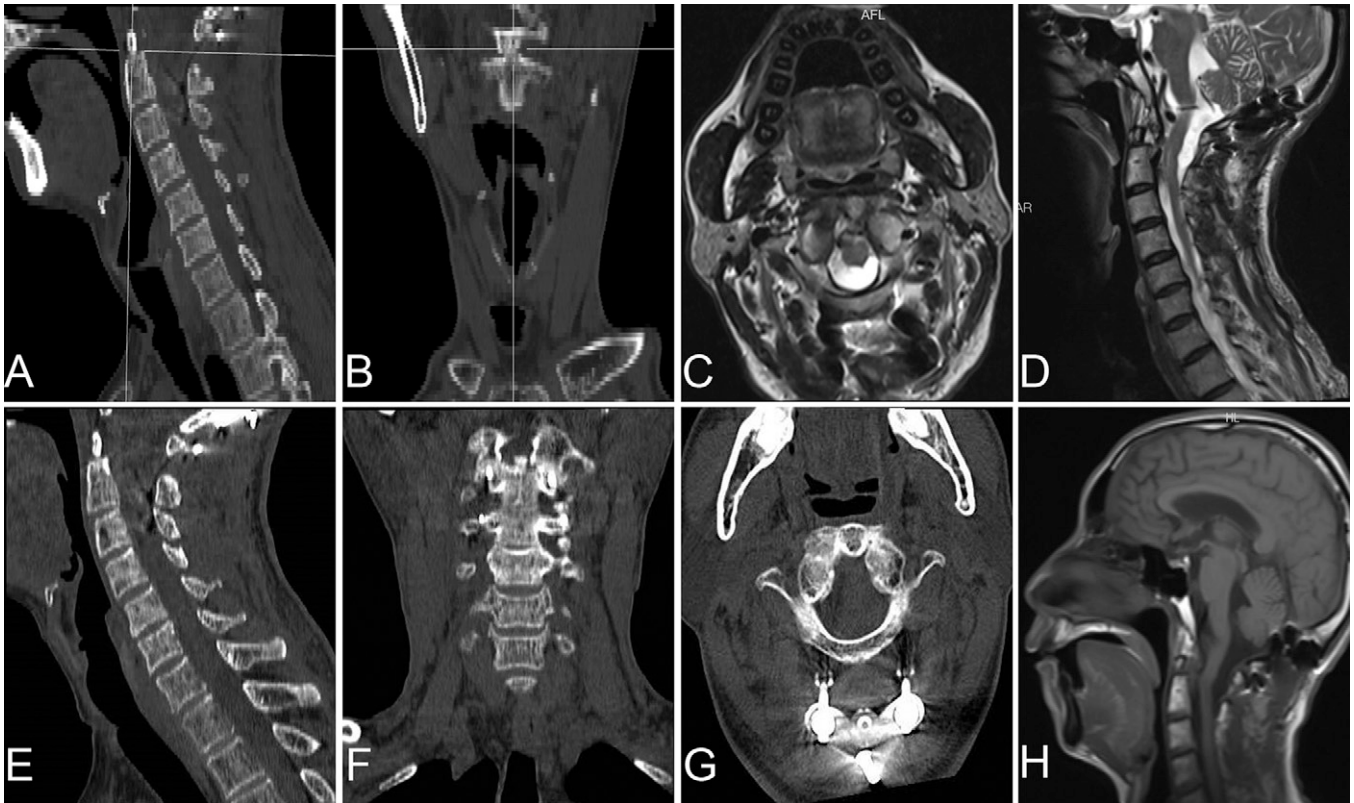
At the 3-month follow-up, CT revealed bony fusion between the lateral joints of C1–2 and between the root of the resected odontoid process and the anterior arch of C1 (A and B). MRI showed an arachnoid cyst lying posterior to the cervical cord at the level of C1–2 (C and D). At the 12-month follow-up, CT showed more solid bony fusion than at 3 months (E–G). MRI showed that the size of the cyst had no significant changes compared with the previous scan (H).
